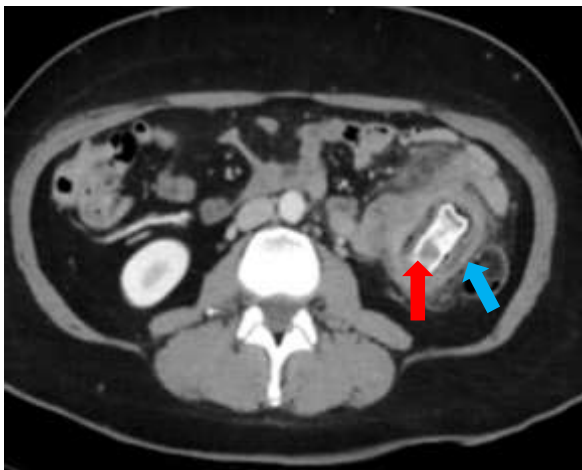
CT axial image showing suspected foreign body (red arrow) and surrounding contained perforated diverticulum (blue arrow).
